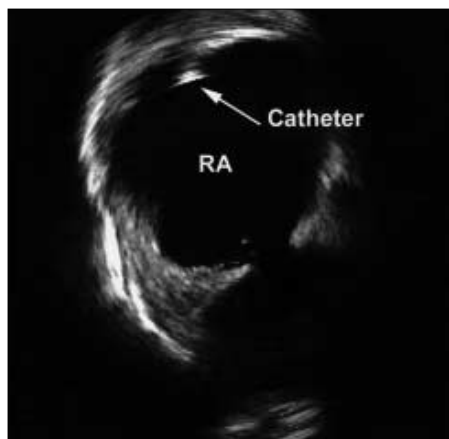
Intracardiac echocardiographic view of the Revelation T-x ablation catheter in the right atrium showing good wall contact
